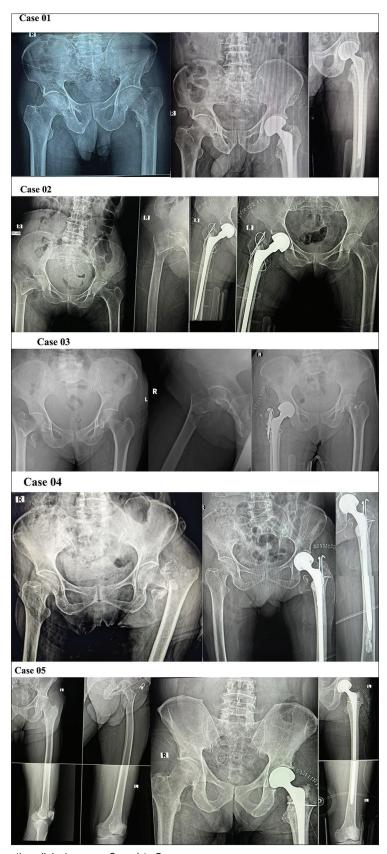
Radiographs of representing clinical cases – Case 1 to 5
